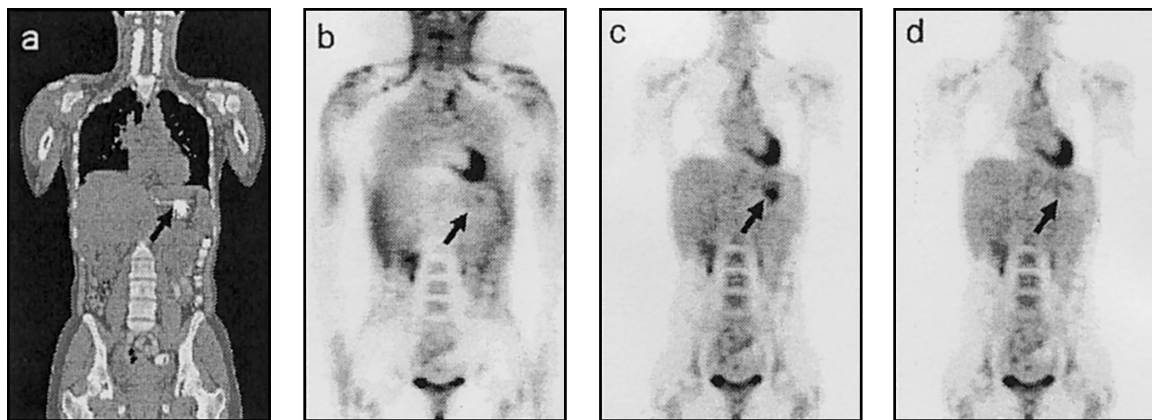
Effect of contrast agent accumulation. (a) CT image showing regions of highly enhanced CT values due to a focal accumulation oral contrast in stomach (arrow). (b) PET image without attenuation correction. (c) PET image with CT-based attenuation correction using the hybrid method. (d) PET image using CT-based attenuation correction with contrast-agent enhanced CT values set to 0 HU by using an automated region-growing segmentation algorithm.⁴³ Courtesy of Jonathan Carney, PhD.
